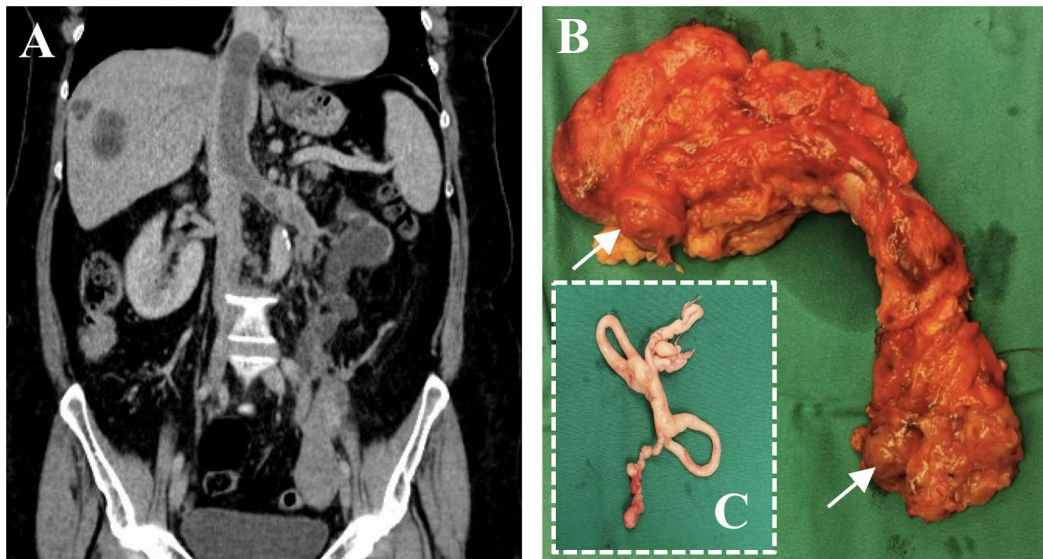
(A) Coronal contrast-enhanced CT image of the abdomen and pelvis showing pelvic tumour, atrophic left kidney with dilated ureter, filling defects of IVC and left renal vein, (B) the removed left kidney with a distended left ovarian vein and left renal vein, the vessels are obliterated with tumour visible at the edges due to venous wall retraction (arrows), (C) the cavoatrial smooth malignant thrombus.
